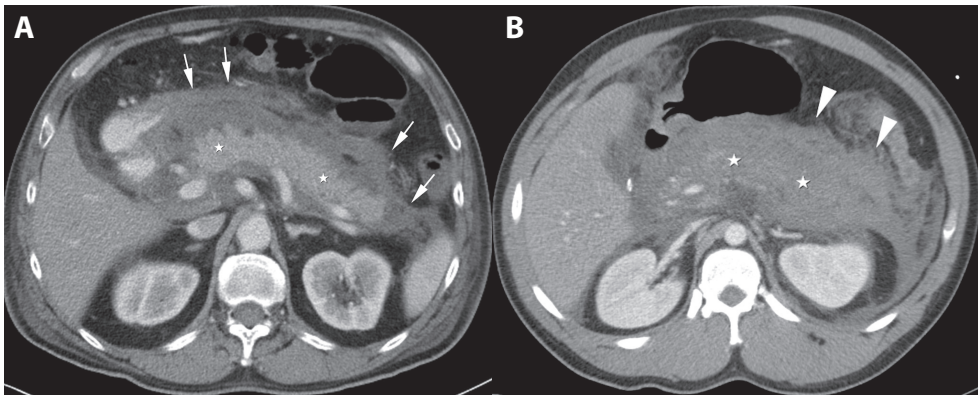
(A) A 41-year-old man with acute pancreatitis (CTSI 4). Contrast-enhanced CT shows a normal enhancing pancreatic parenchyma (white stars) with more than two peripancreatic collections (arrows). (B) A 32-year-old man with acute necrotizing pancreatitis (CTSI 10). Contrast-enhanced CT shows extensive pancreatic nonenhancement (white stars), representing pancreatic necrosis. More than 50 % of the pancreatic volume is involved in the necrotic process. Peripancreatic collections (acute necrotic collections) are present (arrowheads).
